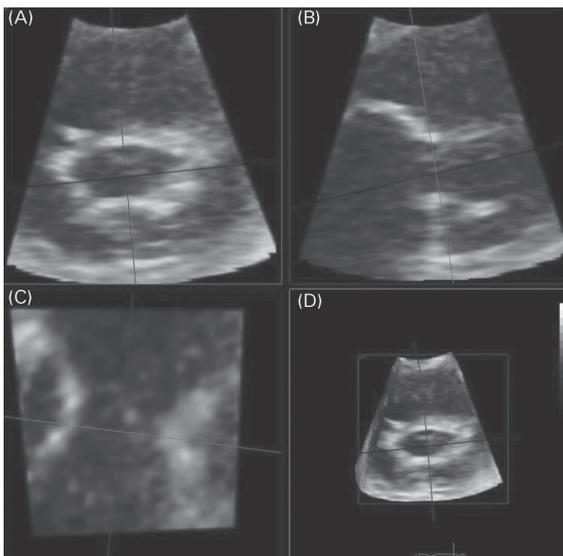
Image source: Textbook of Clinical Echocardiography (Otto)
